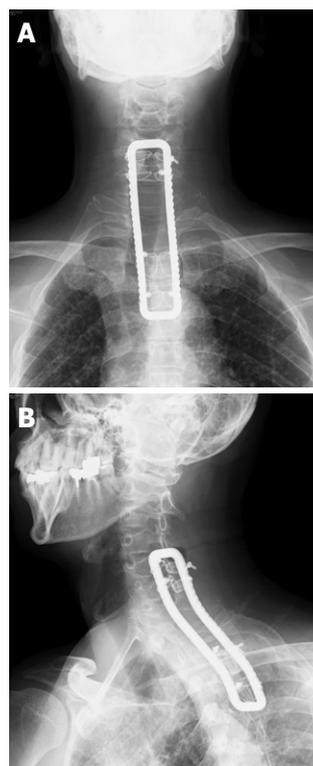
Radiography after first surgery. The laminectomy of C7, Th1 and Th2 and fixation of C5-Th4 were performed by using a sublaminar wire and a rectangle rod. A: Anteroposterior view; B: Oblique view.
